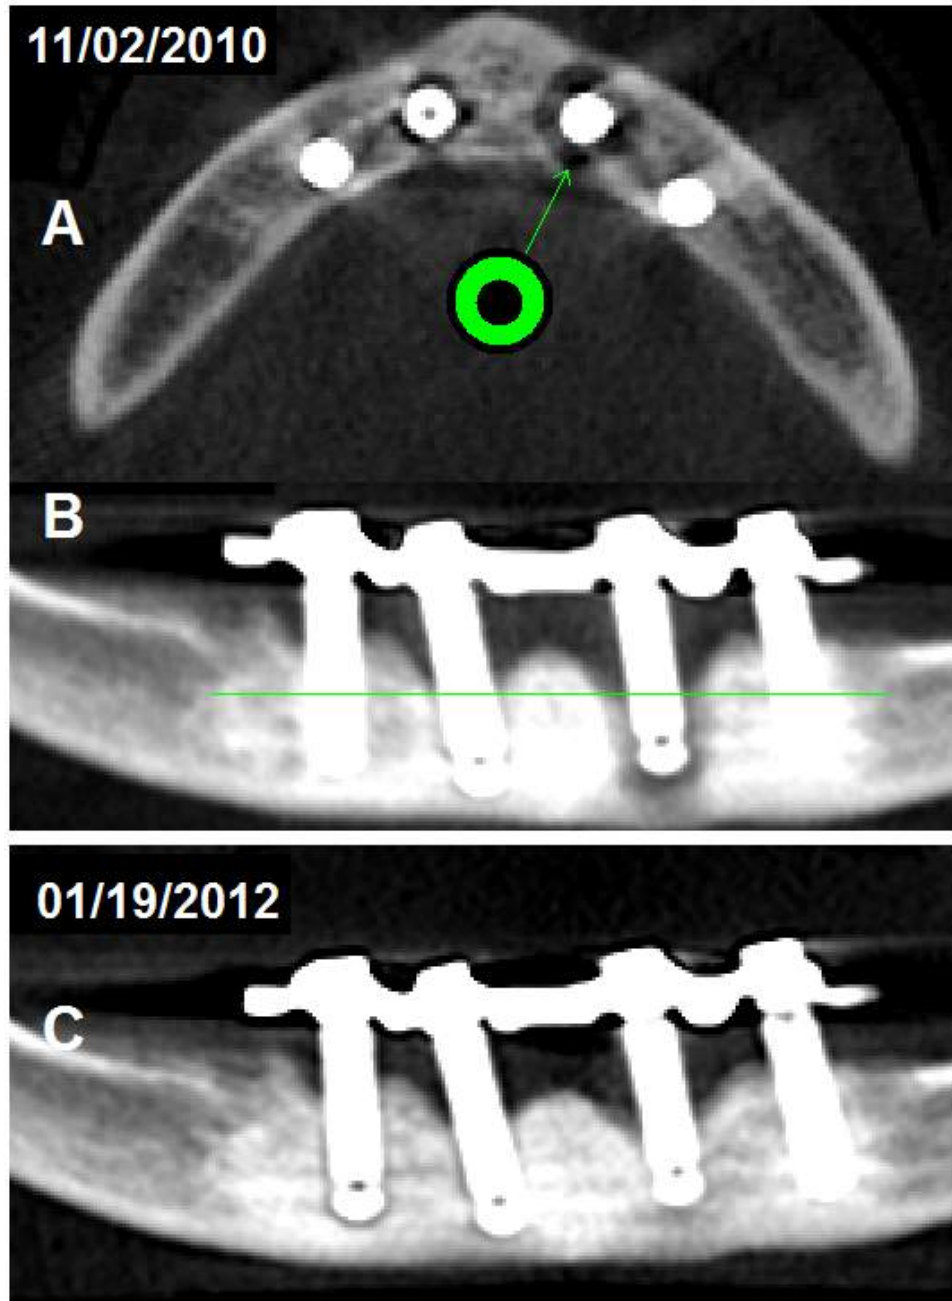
CT scan showing peri-implantitis in the anterior mandible of a 48 year old male.
